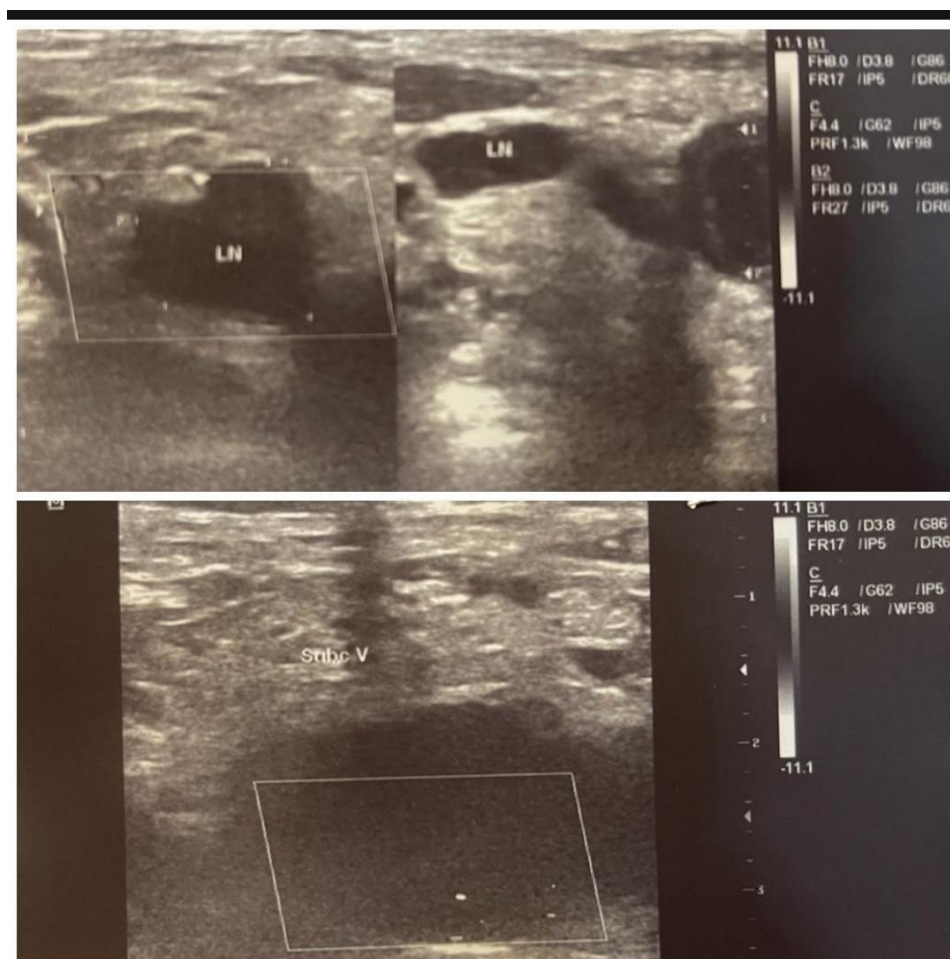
Color Doppler revealed no flow in right subclavian vein and lymphadenopathy on USG neck
